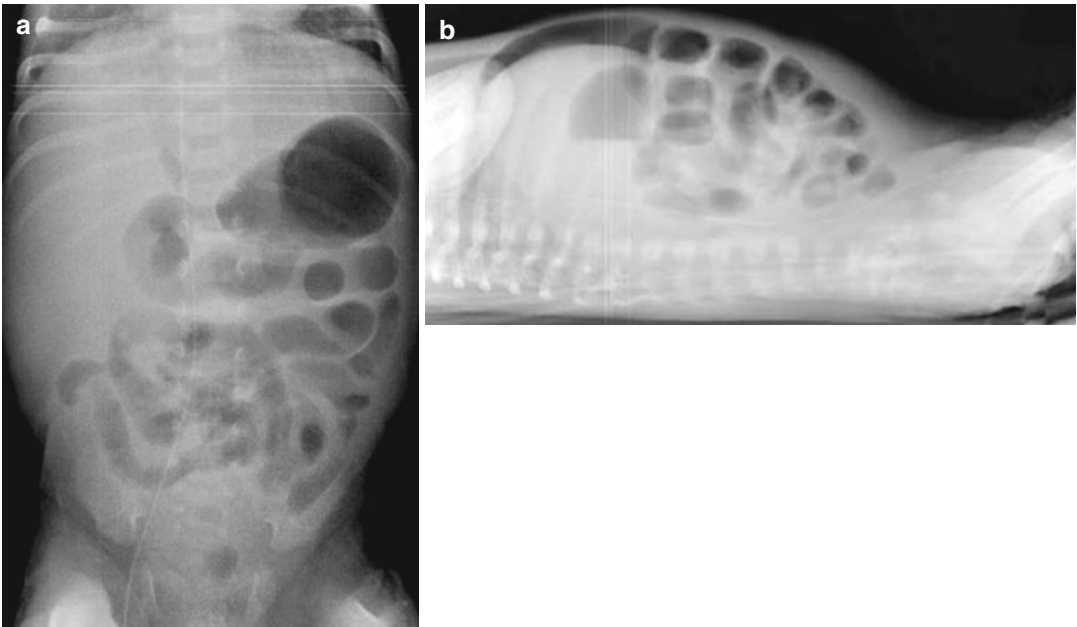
Plain abdominal radiographs: supine antero-posterior view (a) and trans-lateral view (b) show the presence of pneumoperitoneum
